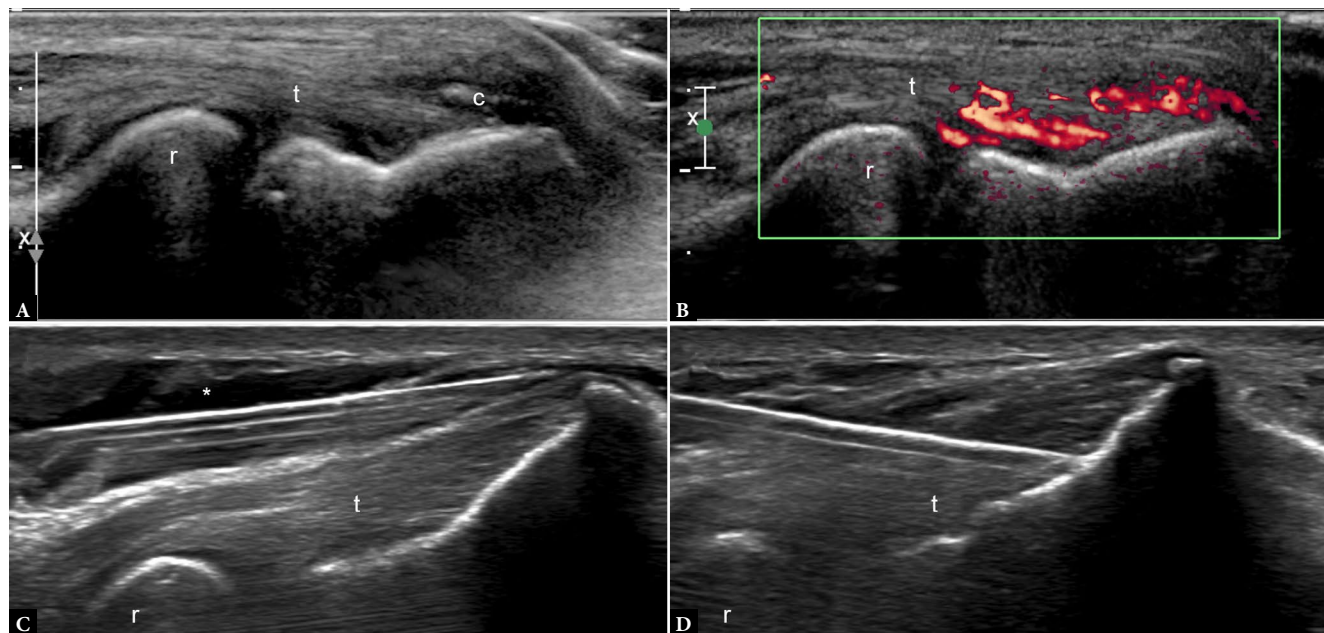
Ultrasound long-axis view showing the two interventions. A. pre-treatment with focal thickening, hypoechogenicity and calcifications (c) of the extensor tendon. B. pre-treatment with tendon hyperemia on color Doppler. C. Hydrodissection with injection of lidocaine (*) on the whole surface of the common extensor tendon. D. Percutaneous needle tenotomy with a 21G needle perforating the common extensor tendon. r – caput radi; t – common extensor tendon
